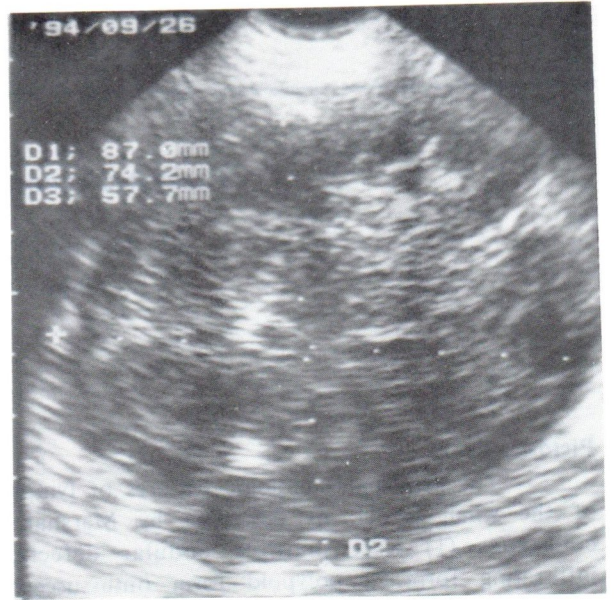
Ultrasonography in the region of the mass showed round mixed hypo and hyper-echoic pattern.
